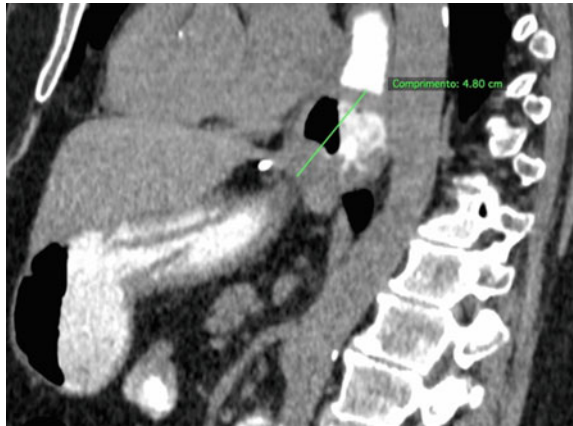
Recurrent hiatal hernia showed in a high-resolution computed tomography; A anteroposterior diameter of hiatus; B lateral diameter of hiatus
